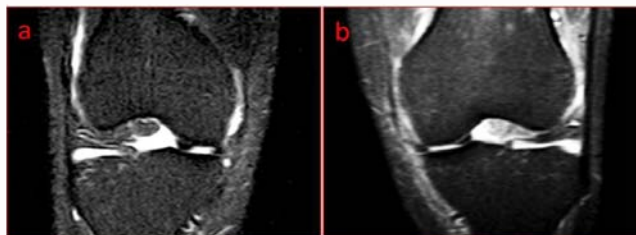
(a) Preoperative MRI frontal scan of the right knee showing a bucket handle tear of the medial meniscus; (b) Preoperative MRI frontal scan of the left knee showing a bucket handle tear of the medial meniscus.
